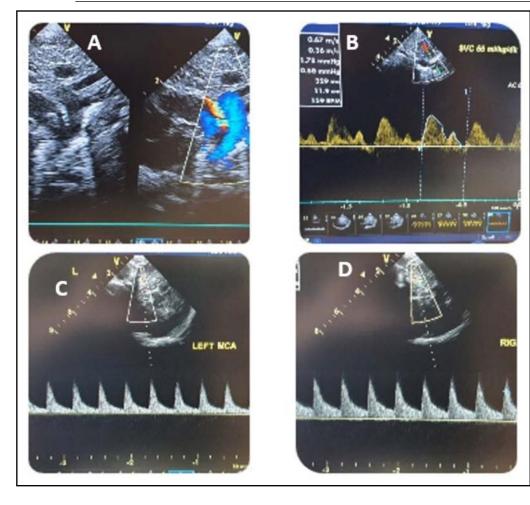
A. Patent ductus arteriosus (PDA). B. Measurement of superior vena cava flow. C. Left middle cerebral artery Doppler imaging. D. Right middle cerebral artery Doppler imaging. Note the rapidly rising and pointed appearance of peak systolic velocity (PSV) in the presence of PDA.
